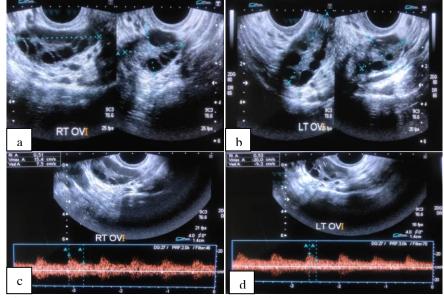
Transvaginal Doppler sonography images; (a and b) longitudinal and transverse B-mode scan to estimate ovarian volume at the obese female; (Right ovarian volume is 17.4 cm³ and left ovarian volume is 15.2 cm³, (c & d) doppler examination images for ovarian artery, showed RI (0.51 and 0.53 for the right and left respectively).
